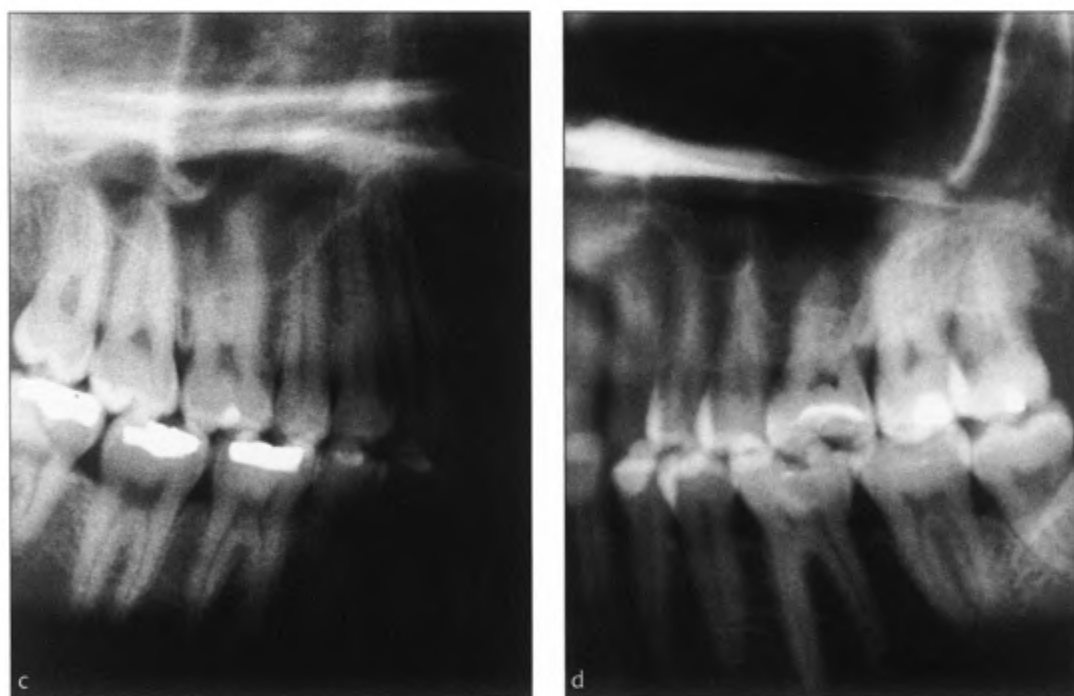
Extract from orthopantomogram in the region of maxillary sinus: radiological diagnosis.
